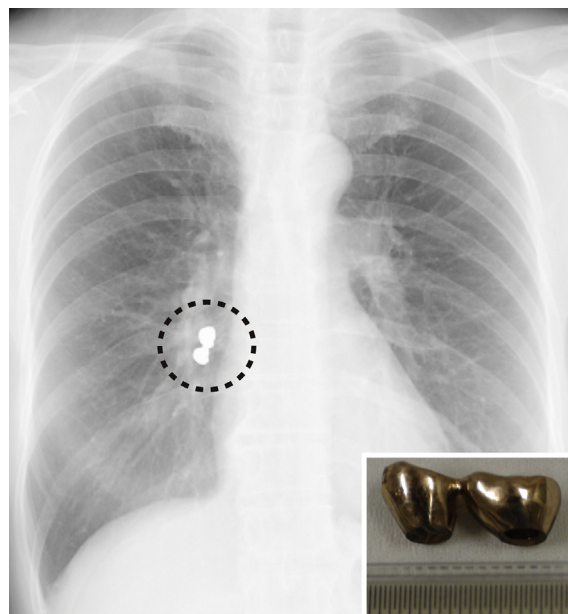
Chest radiograph showing a radiopaque object in the right lung hilum (dotted circle). The inset image shows the retrieved dental prosthesis, 20 mm × 10 mm, with a scale.
